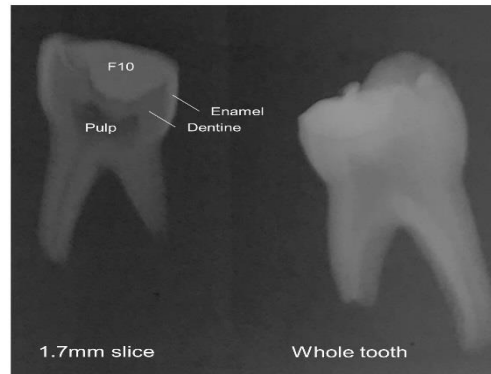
X-ray of primary tooth filled with F10 upon slight removal of carious dentine using ART technique
